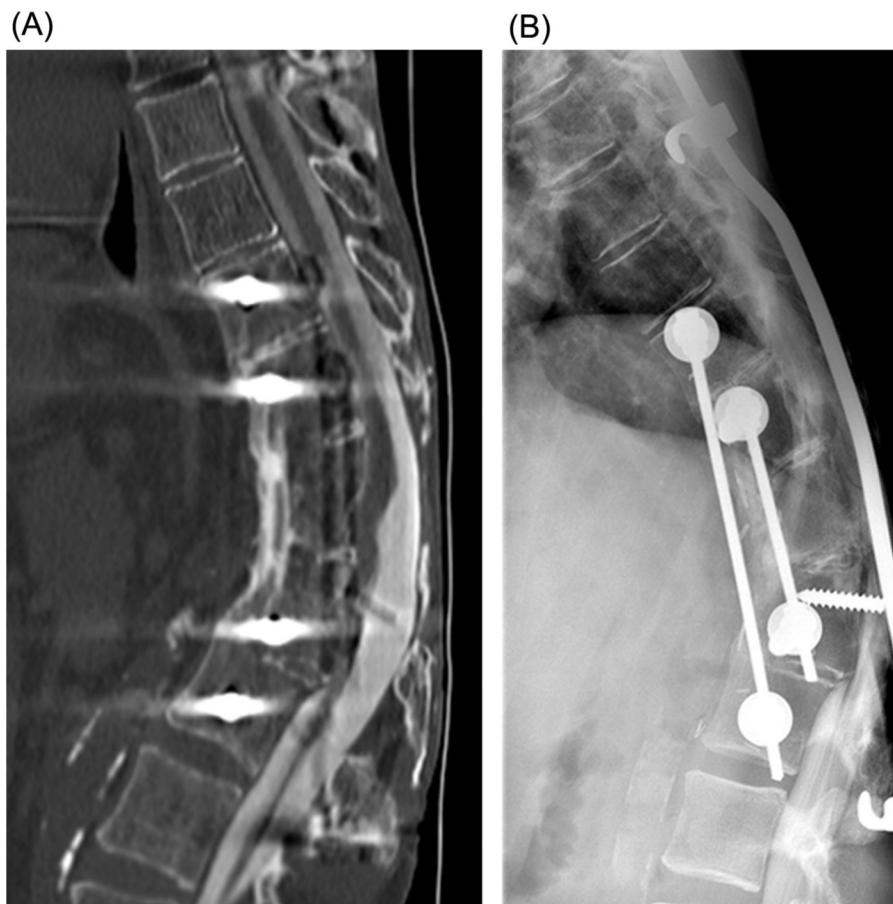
(A and B) CT-myelogram of the thoracic spine: CT-myelogram performed in 55 year old female with continuous thoracic pain after a resection of thoracic lesion. Despite the hardware causes some artifacts the kinking of the thoracic cord can be well seen on the CT-myelogram (A) compared to the fluoroscopic image (B) obtained after the injection of contrast media.
